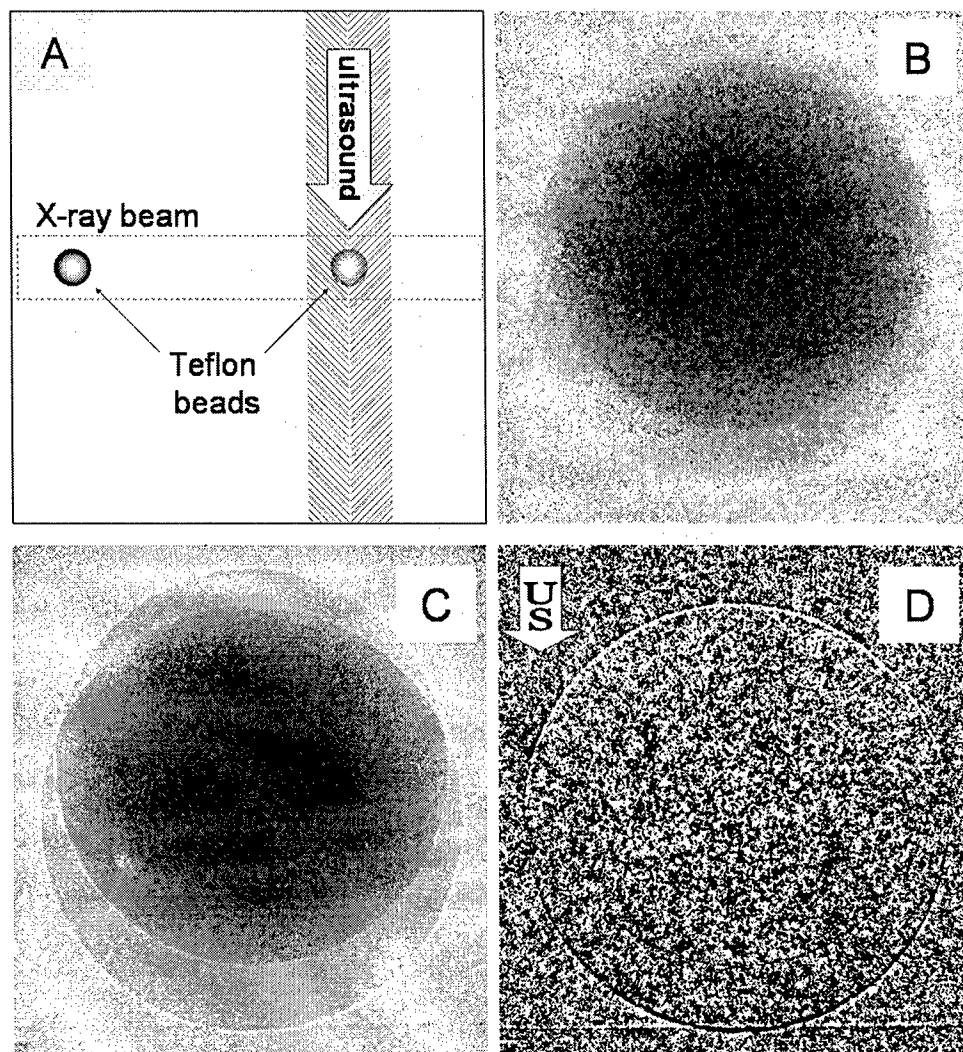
(A) Side view of the sample consisting of two Teflon beads cast in agarose. The two beads are separated by 3 cm. (B) Image of the beads with no phase contrast. (C) Image of the beads with phase contrast. (D) Subtracted image of the two beads. The bead irradiated with ultrasound is nearest the CCD camera and produces a slightly larger image than the bead located outside the sound beam. The x-ray tube voltage for the images was 90 kV. The image in (B) was taken with a 75 s exposure time with the x-ray tube operating at 80 W; the image in (C) was taken with eight times lower tube wattage and eight times longer exposure to give the same total x-ray fluence.
